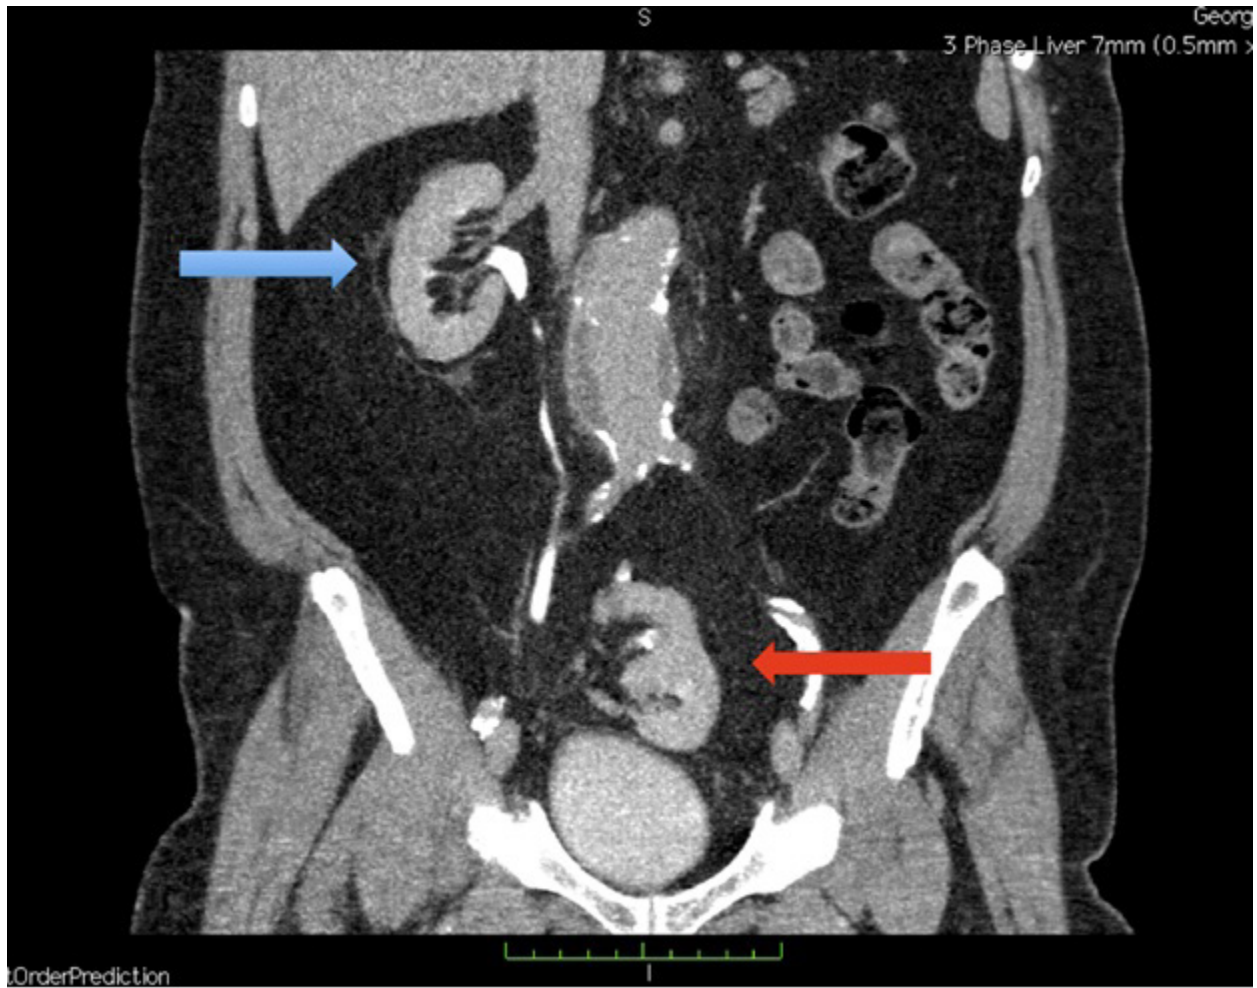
Preoperative CT scan: arrows indicate the normal right kidney (left blue arrow) and ectopic pelvic kidney (right red arrow).
